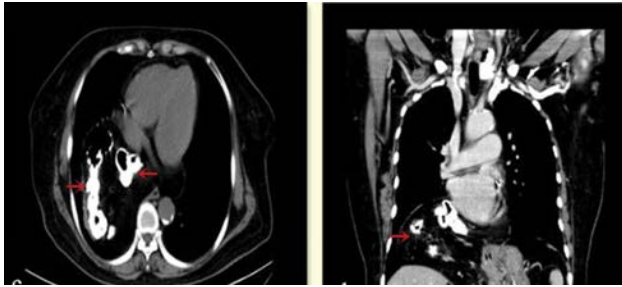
Chest CT, the red arrow indicates a huge mass containing air and barium in the chest.
